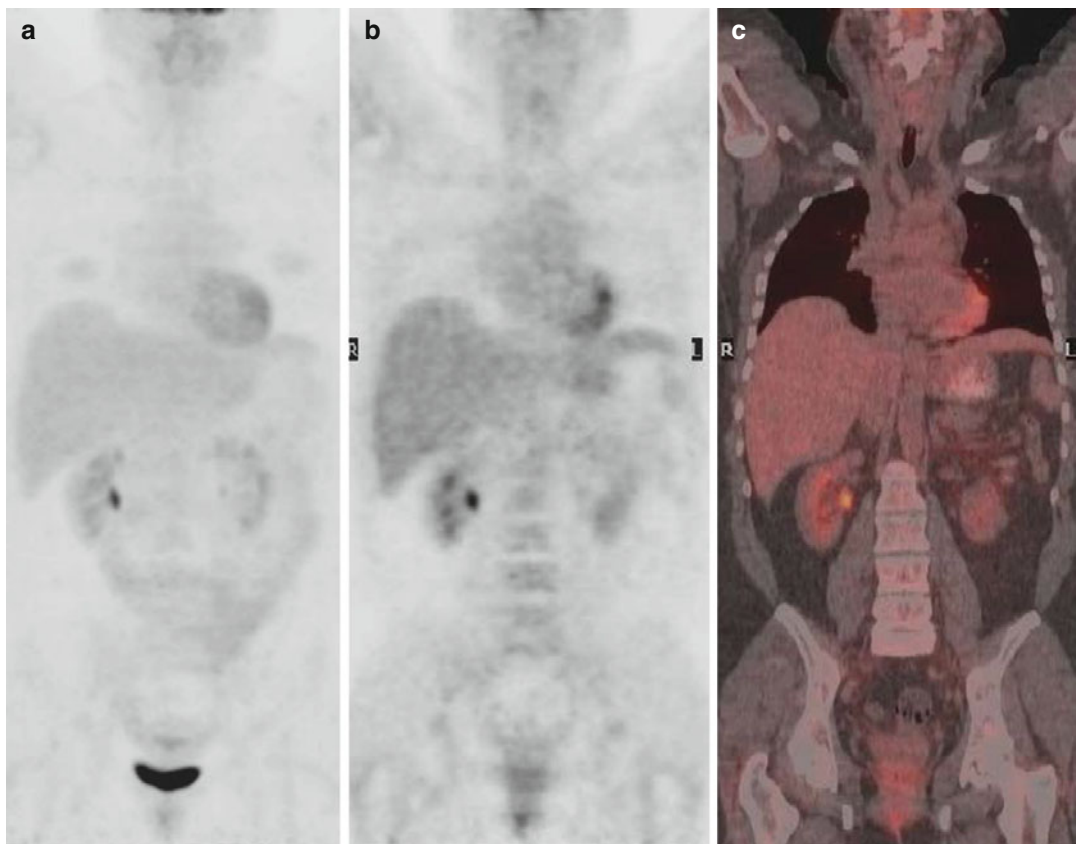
(a–c) PET/CT after the end of chemotherapy was completely negative
